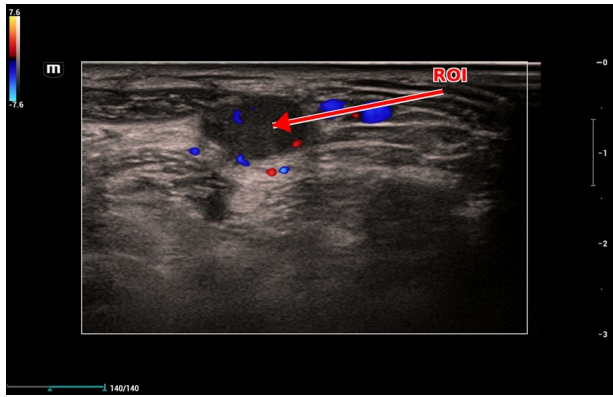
Representative color Doppler ultrasound image used for route planning. The arrow indicates the target ROI selected after assessment of vascular distribution.
